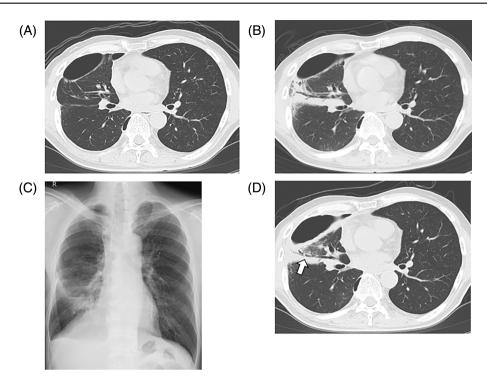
Imaging findings. (A) Residual thoracic airspace (RTS) in the right chest cavity on computed tomography. (B) Enlarged RTS at 12 months after surgery. (C) An air-fluid level was apparent on a chest roentgenogram at 13 months after surgery. (D) The responsible bronchus (arrow) of fistulous pyothorax in the right middle lobe.
